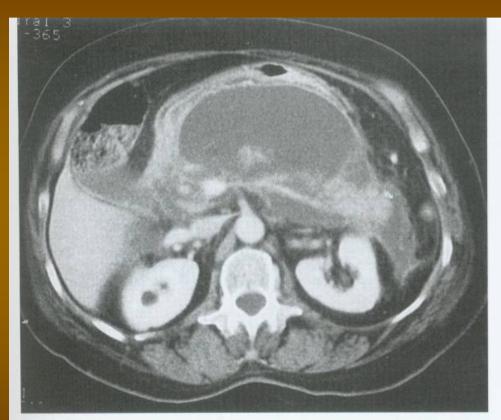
A computed tomography scan of a patient with a large retrogastric pancreatic pseudocyst. The patient had symptoms of abdominal pain, back pain, nausea, and early satiety.
